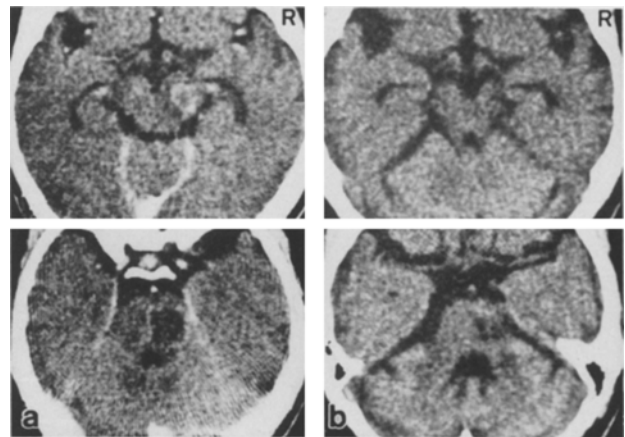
a, b. Enhanced CT scans of case 1. The left row (a) shows enhanced CT 10 days after onset of clinical symptoms. The right row (b) shows enhanced CT about 11 months after onset of clinical symptom. a A unilateral low density area with marginal enhancement effect is noted in the brain stem (lower pontine base-midbrain cerebral peduncle) and the pontine swelling is significant. The structures involved in this case are pontine base, pontine tegmentum and cerebral peduncle in the right side. b A small low density area is seen in the right brain stem (lower pons up to cerebral peduncle). There was no definite enhancement around the low density area. The brain stem is atrophic with widened cisterns
